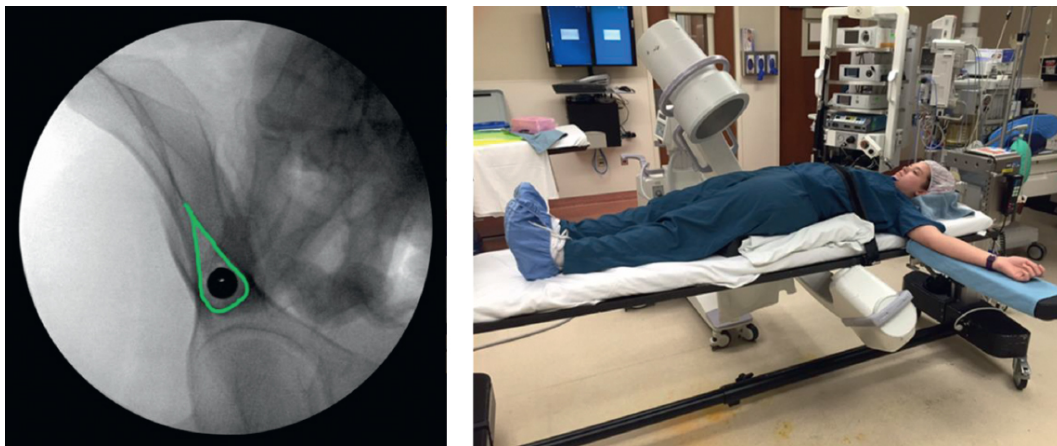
This obturator-outlet fluoro view shows the “teepee” radiographic outline of the AIIS when visualized straight on, denoting the proper starting point for supra-acetabular fixation. A clinical demonstration of a right obturator-outlet view is shown.
